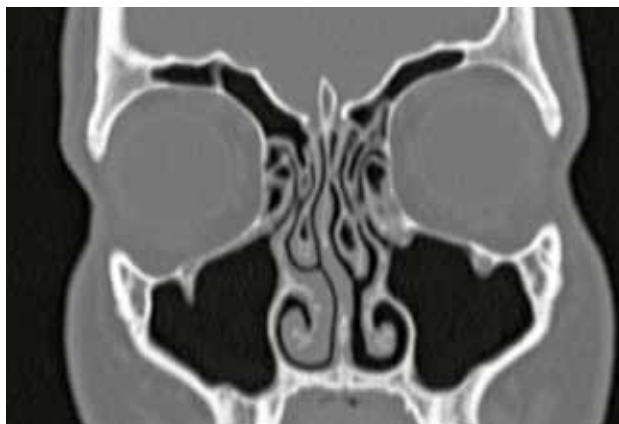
Coronal CT of paranasal sinuses.
